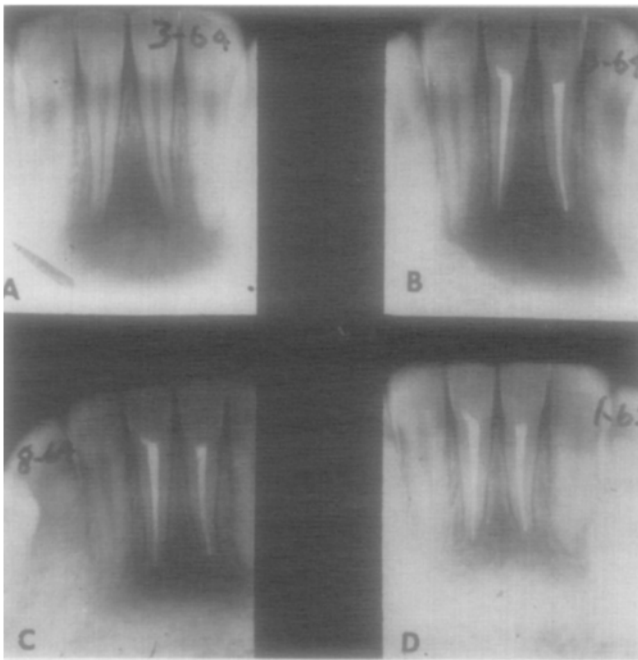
A, Diagnostic roentgenograms. Note extensive rarefaction and root displacement of central incisors. *B*, Endodontic therapy completed. *C*, Follow-up roentgenograms 5 months after treatment. *D*, Roentgenographic evidence of resolution 10 months after treatment.
